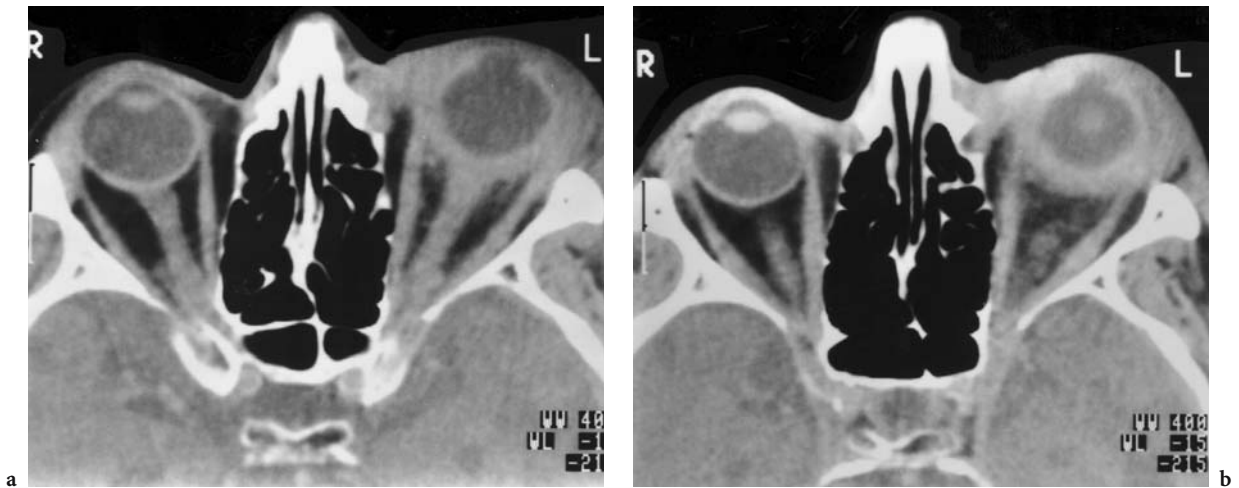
A 48-year-old male car accident victim. Diagnosis: luxation of the lens, episcleral and retrobulbar hematoma. Axial CT: a Note the dislocation of the lens into the vitreous body as well as conjunctival hematoma, and in b thickening of the sclera due to the presence of an episcleral and retrobulbar hematoma, as well as the asymmetrical width of the globe when compared with the right side
